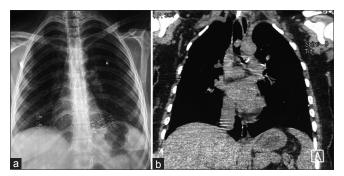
(a) Posteroanterior chest radiograph is essentially normal. (b) Computed tomography thorax demonstrating a large globular endoluminal soft tissue causing near complete occlusion of the lower trachea
